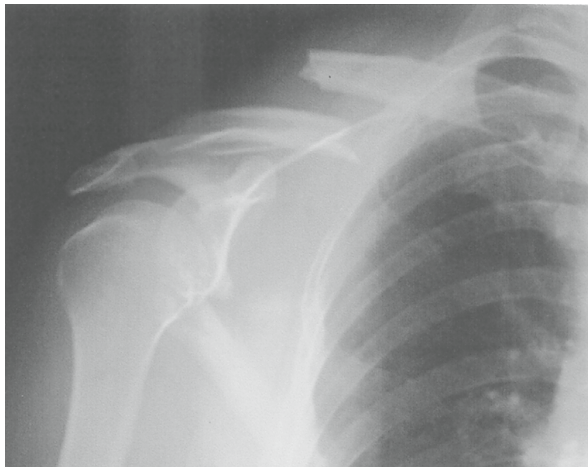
Radiograph showing right floating shoulder with scapular neck and ipsilateral midclavicular fractures. (From Hashiguchi H, Ito H: Clinical outcome of the treatment of floating shoulder by osteosynthesis for clavicular fracture alone, *J Shoulder Elbow Surg* 12(6):589-591, 2003.)
